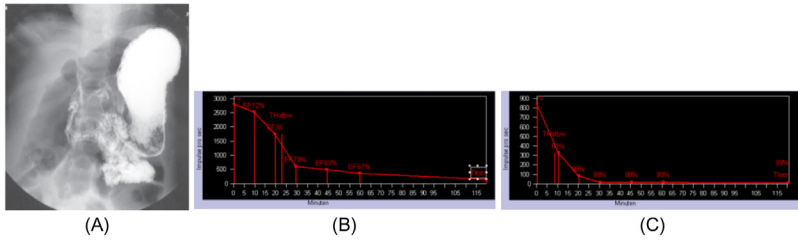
Gastroparesis: (A) Significantly enlarged stomach filled with contrast agent in the scintigraphic gastric emptying study; emptying is massively prolonged; (B) gastric emptying study before and (C) 6 months after implantation of the pacemaker. *Courtesy: (A) Dr. K. Holzapfel, Klinikum rechts der Isar; (B, C) Dr. I. Yakushev, Klinikum rechts der Isar.*
